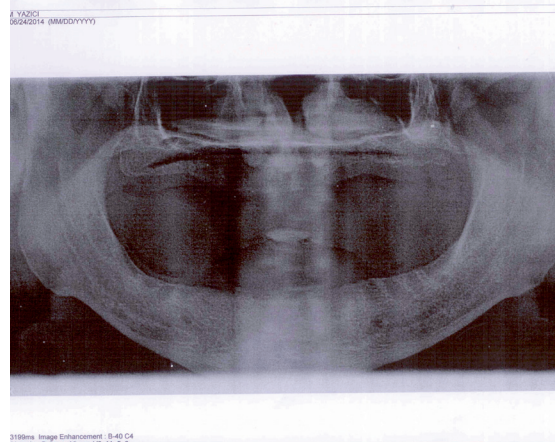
Computed tomography at 4 month follow-up.
